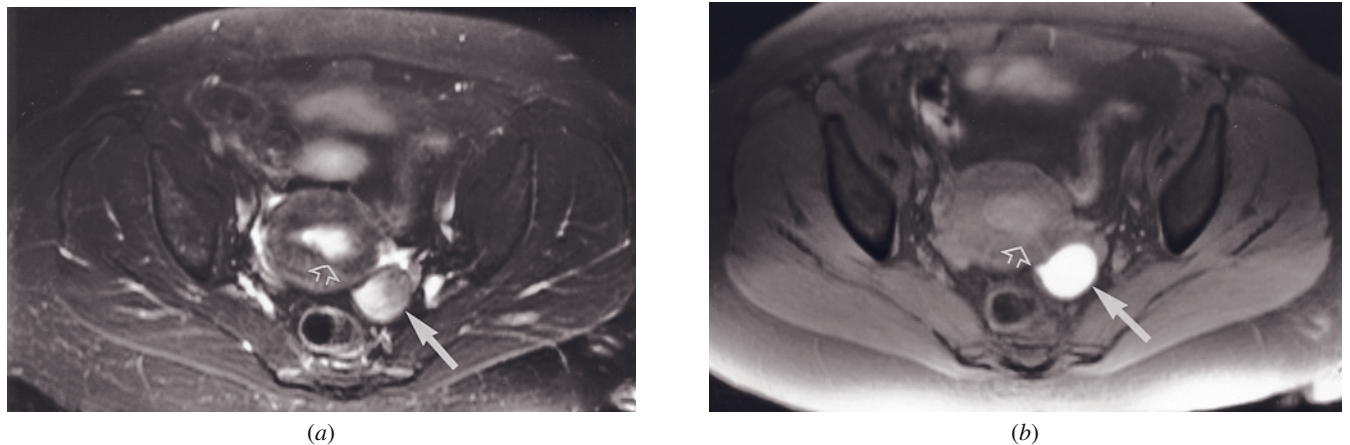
Hemorrhagic cyst in a patient with endometrial carcinoma. T2-weighted fat-suppressed ETSE (*a*) and T1-weighted fat-suppressed gradient-echo (*b*) images. Hemorrhagic cysts can mimic endometriomas with high signal intensity on T1-weighted images (arrow, *b*) and heterogeneous high signal intensity on T2-weighted images (arrow, *a*). Note the endometrial thickening due to endometrial carcinoma with focal thinning of the junctional zone (open arrows, *a, b*).
